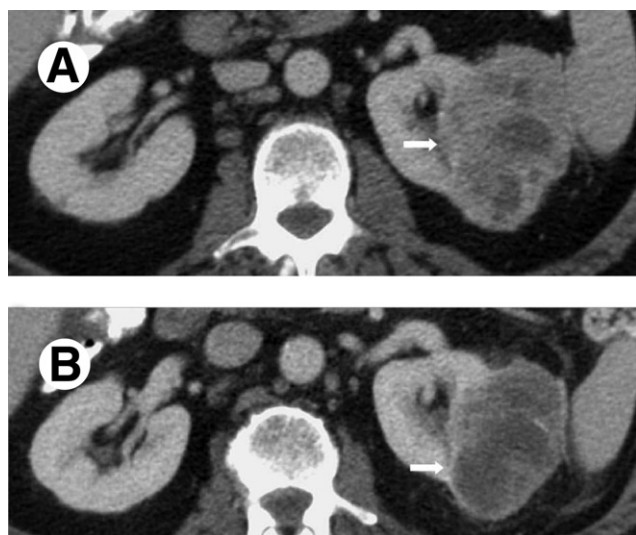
Treatment response in advanced clear cell RCC following sorafenib therapy. Axial contrast-enhanced CT images pre- (A) and post- (B) treatment, showing changes in tumor morphology with increase in tumor necrosis but without significant decrease in tumor size.
